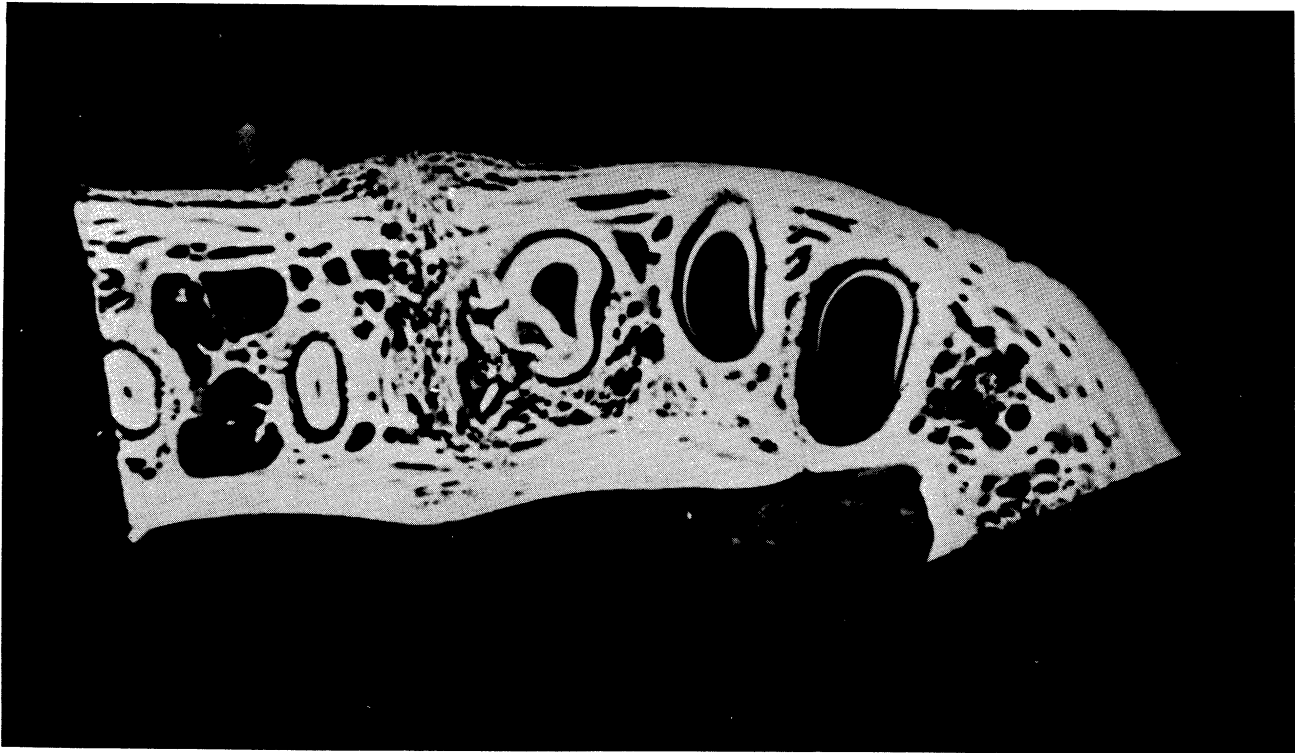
Rigid bony union demonstrated by horizontal section radiograph.
